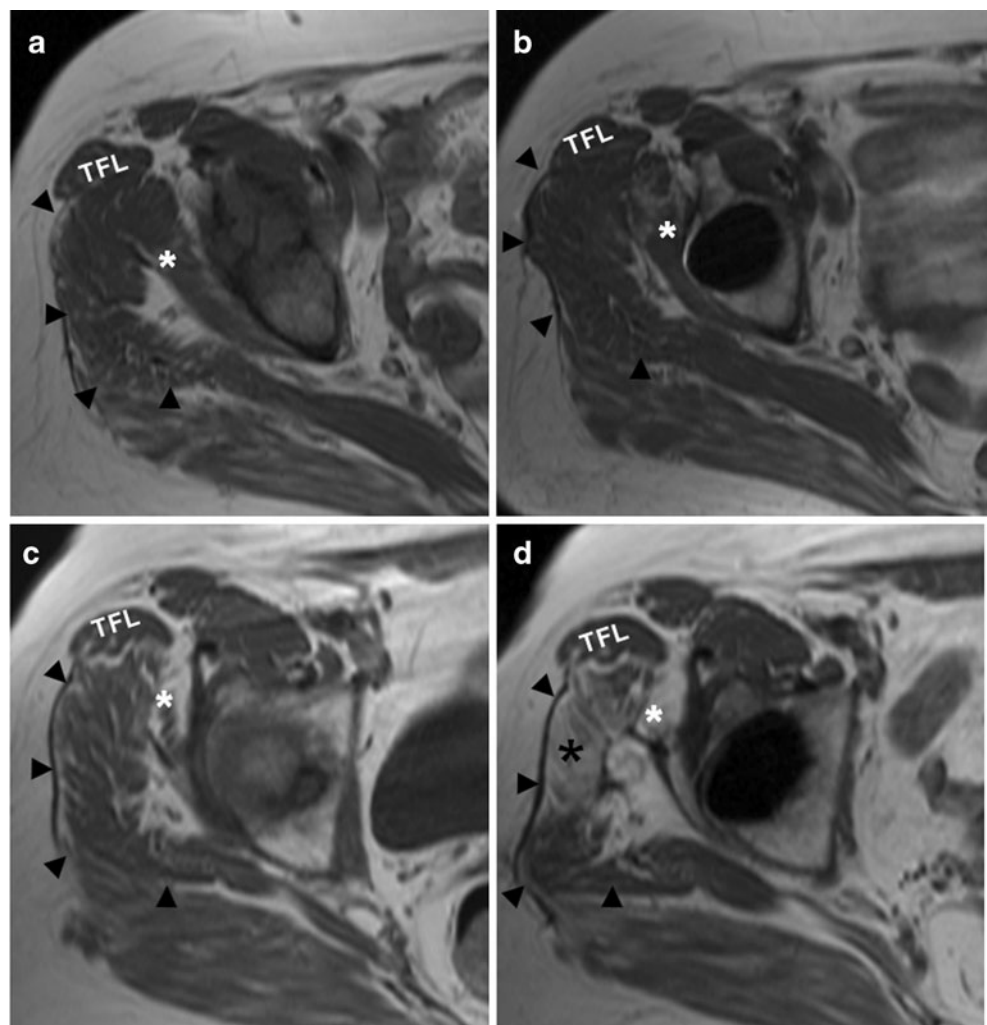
exemplifies pre- and postoperative axial T1-weighted TSE images on height of the acetabulum for a patient younger and one older than 70 years.
